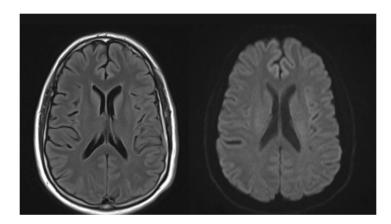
Demonstrates normal MRI of the brain
